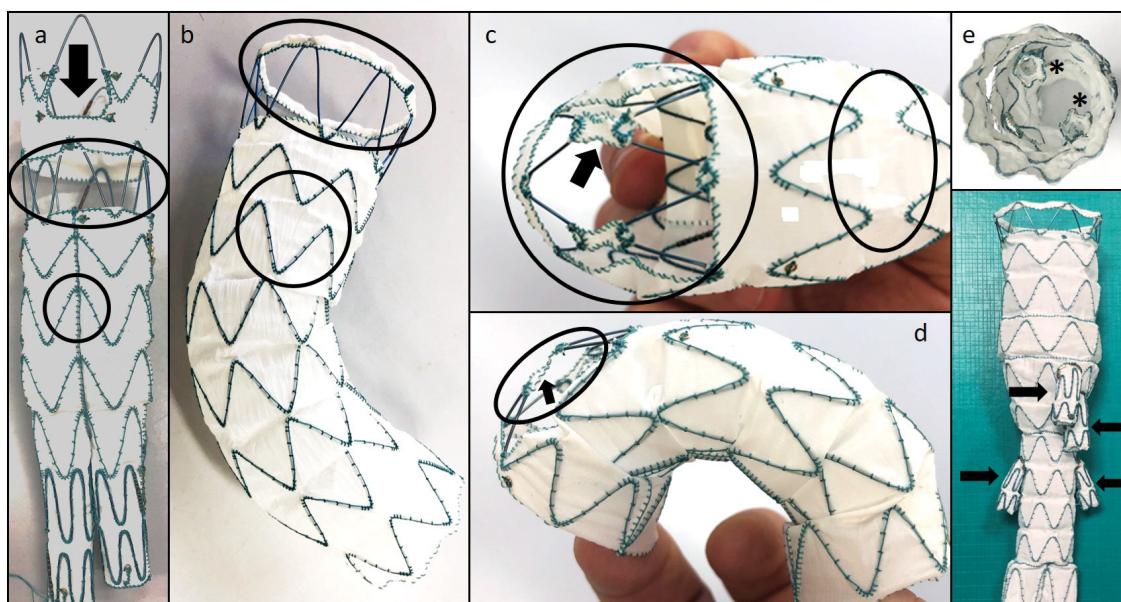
(a) Round ring: independent nitinol stents sewn on a Dacron textile; arrow: scallop at the level of the proximal edge of the ASG for the CT; oval ring: 360° fenestration for SMA and RRAA; (b) round ring: “peak-to-valley” stents orientation; oval ring: interconnection of the apexes of the free-flow with a thin Dacron collar; (c) oval ring: “peak-to-peak” stents orientation; arrow: frontal view of the inter-stents connecting Dacron patch; round ring: frontal view of the 180° fenestration; (d) oval ring: lateral view of the 180° fenestration; arrow: lateral view of the inter-stents connecting Dacron patch; (e) asterisks: view from inside of 2 internal branches; arrows: external branches.
